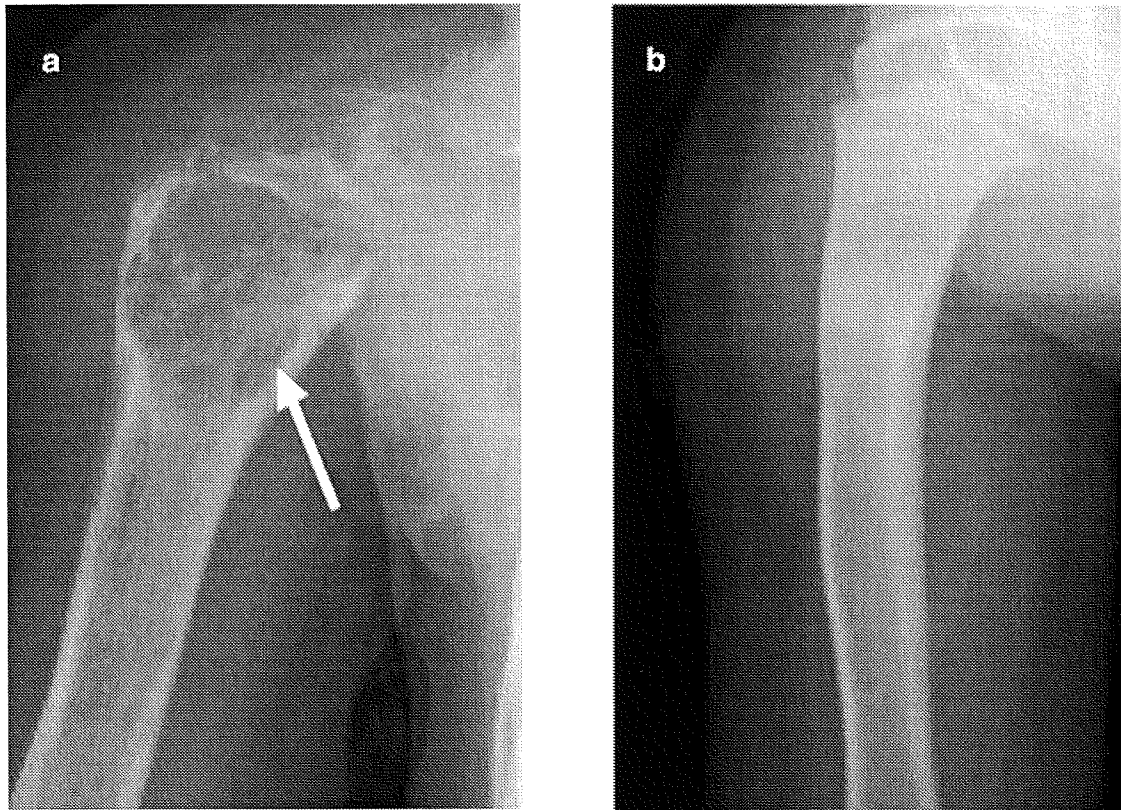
X-ray finding at the proximal right humerus. a: A periosteal reaction with destruction of the normal trabecular bone was found at diagnosis. b: The osteolytic sign resolved completely at 1 year after the treatment.
